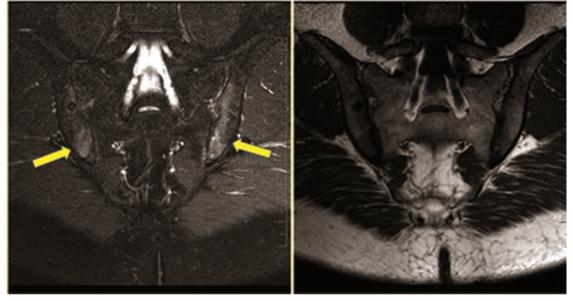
Magnetic resonance images in STIR sequences (left), showing bone edema (osteitis) at both SIJ (arrows); and in sequence T1 (right). SIJ: sacroiliac joints; STIR: short-tau inversion recovery.
